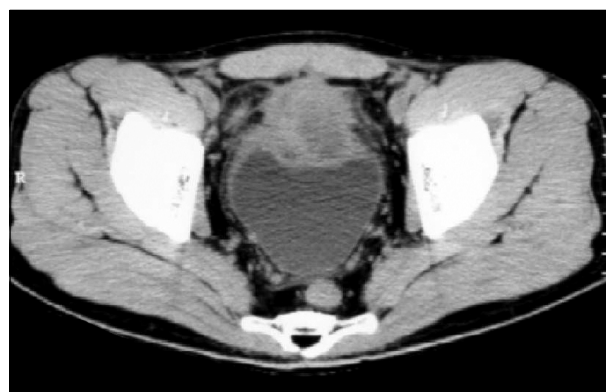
Preoperative computed tomography revealed a urachal mass.
